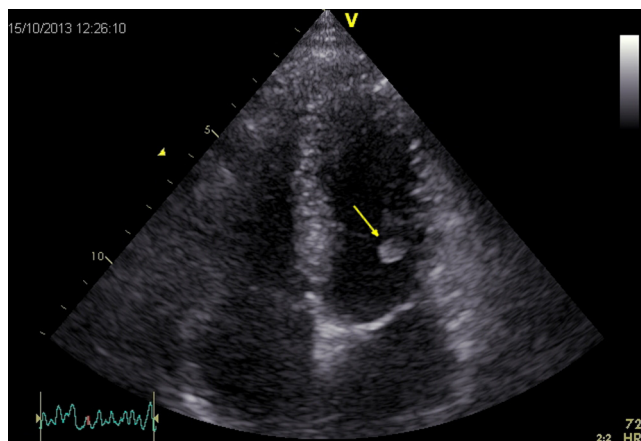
A transthoracic echocardiographic image documenting a pathological spherical mass in the left ventricle close to the basal segment of the lateral wall (arrow) (apical four-chamber projection).
